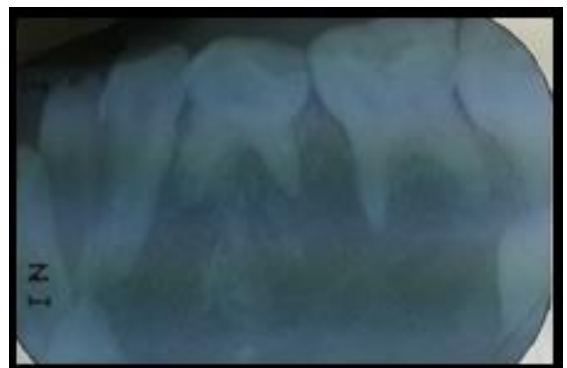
Intraoral Periapical Radiograph
